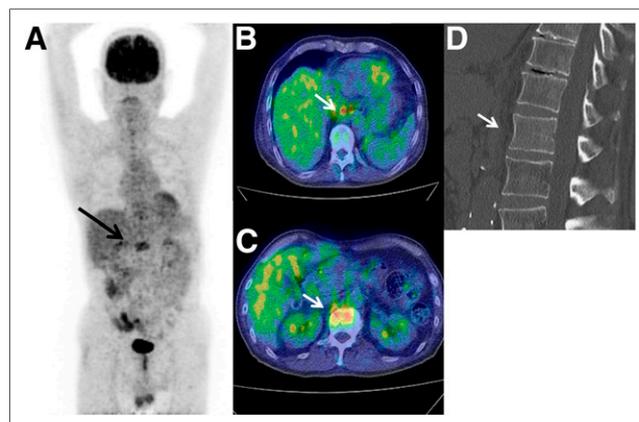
$^{18}\text{F-FDG}$ PET/CT showing relatively high uptake in L1 vertebral body: anterior maximum-intensity projection (A), fused axial delayed-phase images of primary lesion (B) and L1 vertebral body (C), and sagittal CT image of slightly sclerotic lesion in L1 vertebral body (D).
